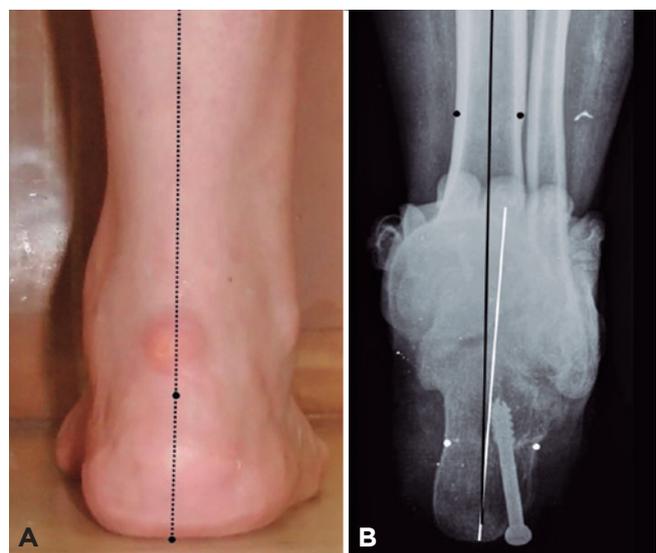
Posterior view of the right leg-foot (Saltzman) of patient 8, showing the clinical (1A) and radiographic (1B) methods for measuring the tibial and hindfoot axes, which are used to assess residual varus after surgical treatment.
